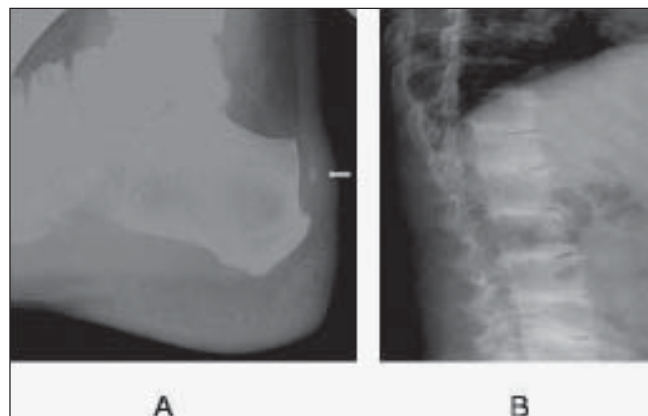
Lateral radiograph of the ankle (A) and dorsolumbar spine (B) showing thickening of the Achilles tendon with a focus of calcification (arrow) and intervertebral disc calcification.
